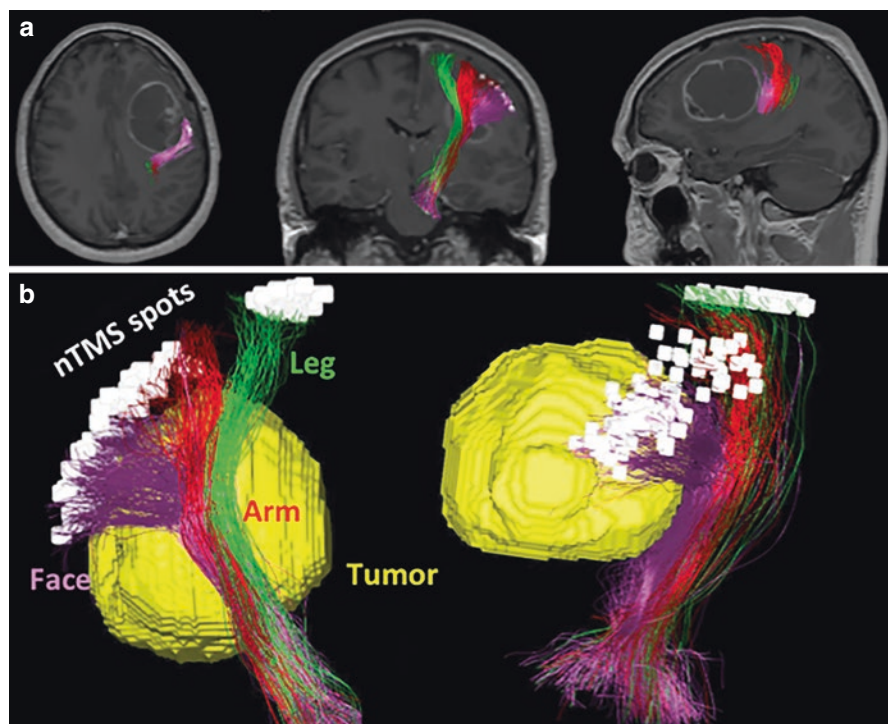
Coregistration of the nTMS-based DTI FT of the CST in the case of a left frontal GBM. (a) Coregistration of the nTMS-based DTI FT of the CST (leg fibers = *green*; arm fibers = *red*; purple fibers = face) with the reference T1-weighted anatomic examination; (b) 3D reconstruction of the CST and its spatial relationship to the tumor (*yellow*). The tumor is located just posteriorly to the CST and involves face fibers (*purple*)
